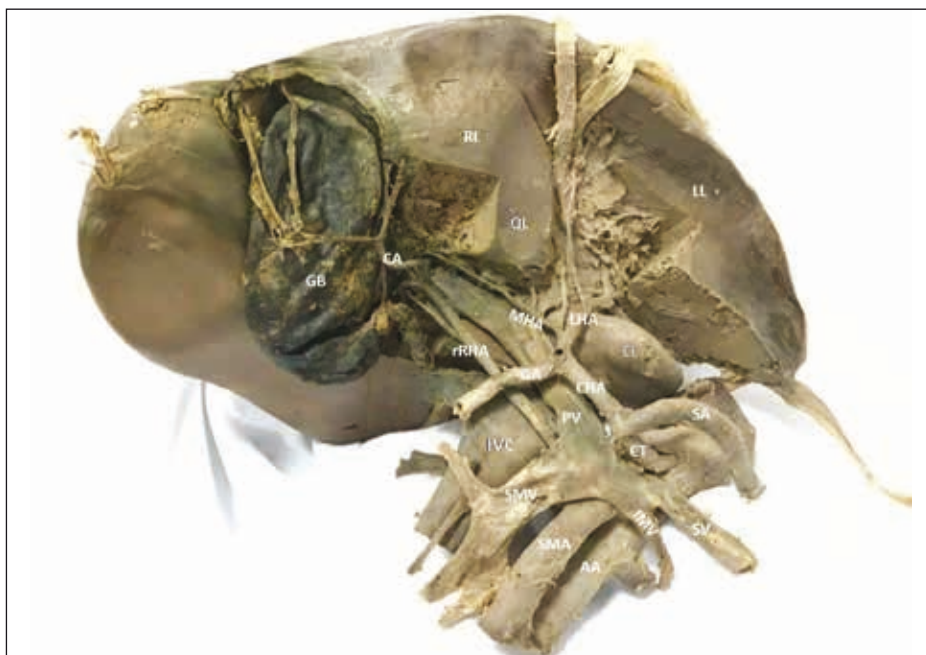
Visceral surface of liver showing the hepatic arteries; AA — abdominal aorta; CA — cystic artery; CHA — common hepatic artery; CL — caudate lobe; CT — coeliac trunk; GA — gastroduodenal artery; GB — gallbladder; IMV — inferior mesenteric vein; IVC — inferior vena cava; LHA — left hepatic artery; LL — left lobe; MHA — middle hepatic artery; PV — portal vein; QL — quadrate lobe; RL — right lobe; rRHA — replaced right hepatic artery; SA — splenic artery; SMA — superior mesenteric artery; SMV — superior mesenteric vein; SV — splenic vein.
